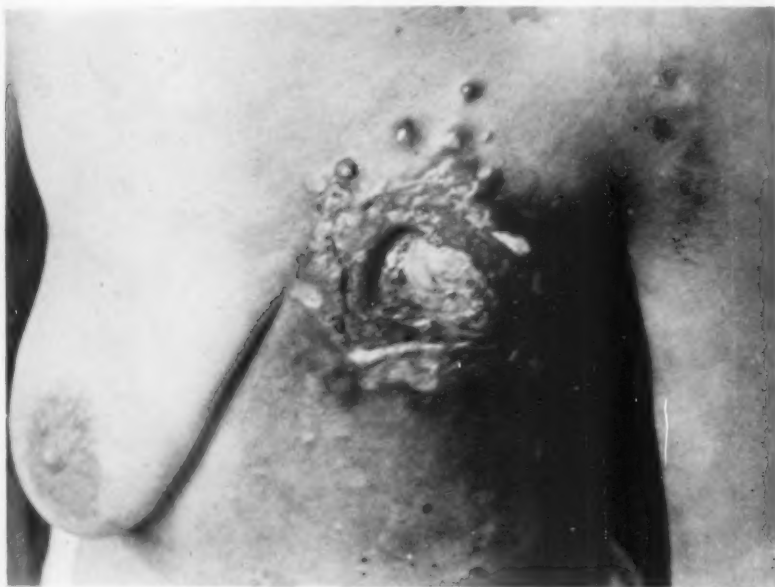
Case No. 77, N. L. Same case as in Figure 7. July 30, 1920, after X-ray radiation, showing marked local effects from radiation.
